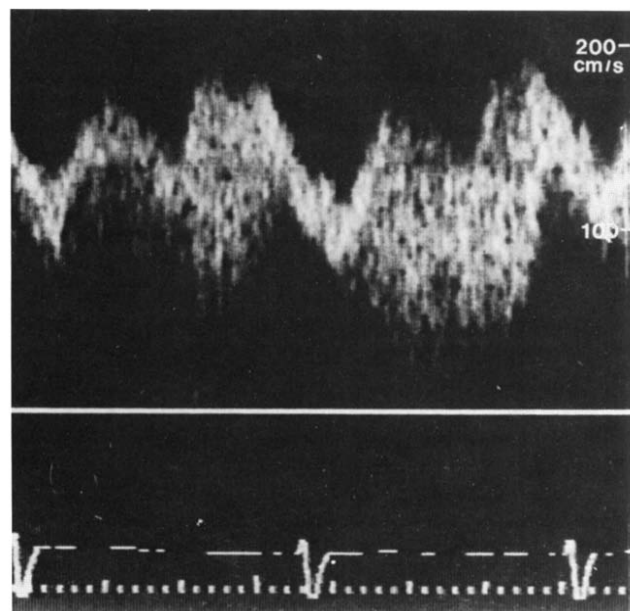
Patient 2: Pulsed Doppler signal at the site of pulmonary venous pathway obstruction showing continuous flow at high velocity throughout the cardiac cycle.
